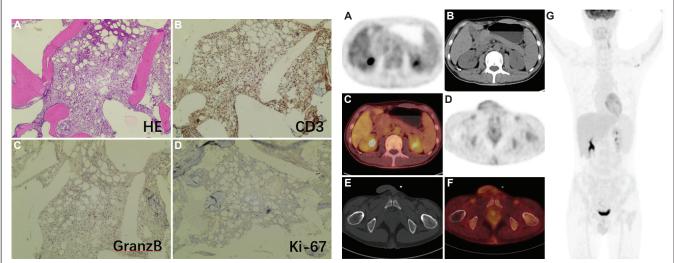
PET/CT images before chemotherapy. Panel A-C show renal PET, CT and PET/CT fusion images, respectively. Panel D-F show PET, CT and fused PET/CT images of the left femoral neck, respectively. (G) MIP image shows abnormal FDG uptake in the bilateral kidneys and humerus, left femoral neck and retroperitoneal lymph nodes. The SUV $_{\rm max}$  of kidney and bone lesions were 18.1 and 17.0, respectively. Arrows indicate lesions. FDG PET/CT, flurodeoxyglucose positron-emission computed tomography, MIP, maximum intensity projection; SUV $_{\rm max}$ , maximum standardized uptake value.
